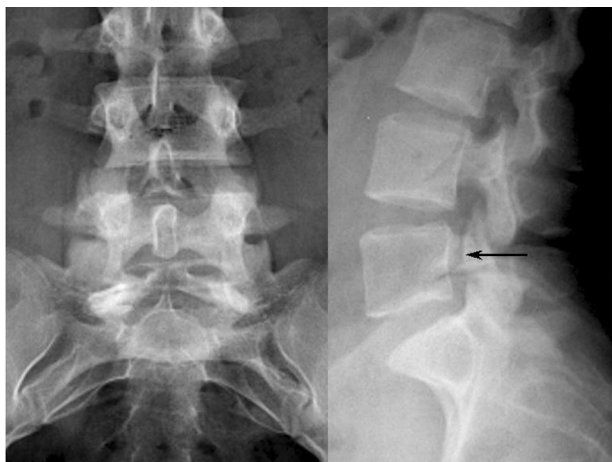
Preoperative plain radiographs are suggestive of L5 pedicle fractures (arrow).
